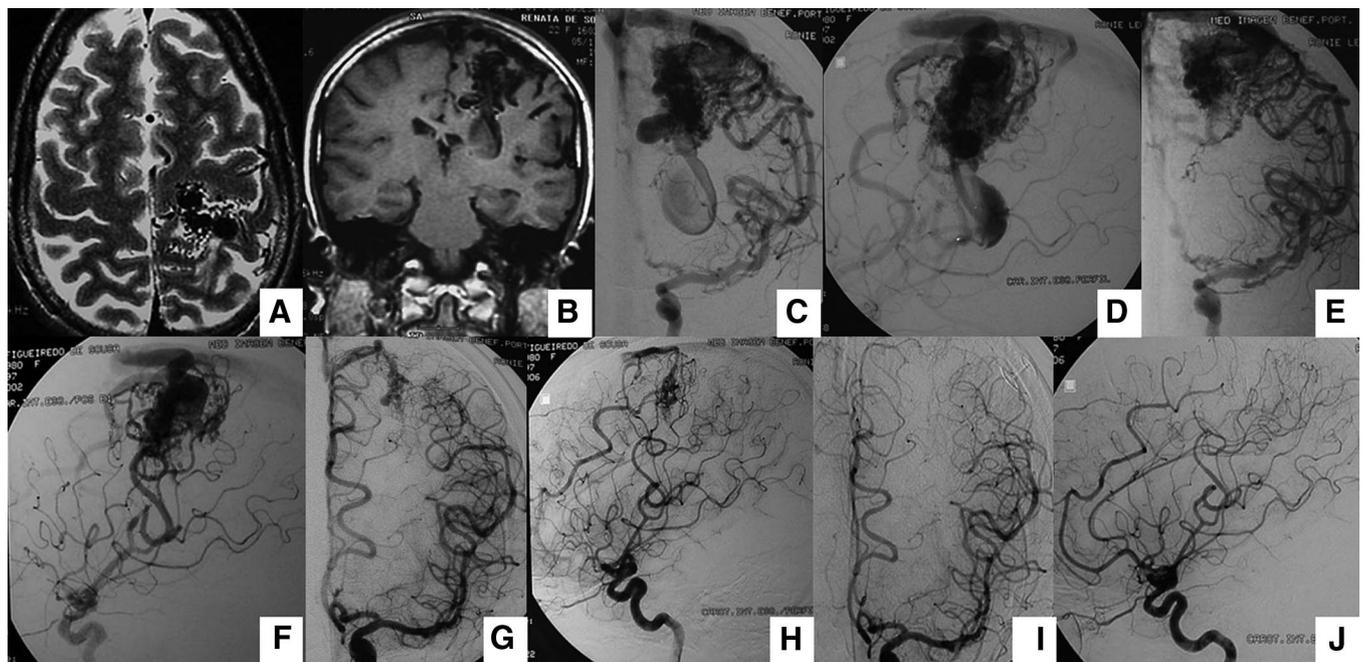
Management of a grade IIIA arteriovenous malformation (AVM) located in the left pre- and postcentral gyri. Axial (A) and coronal (B) magnetic resonance imaging showing the AVM in the left pre- and postcentral gyri. Also note the presence of a large venous aneurysm. Anteroposterior (C) and lateral (D) internal left side carotid angiograms showing an AVM supplied by branches of the middle cerebral artery and the venous aneurysm. The patient was initially treated with embolization (control angiograms shown in E and F), followed by radiosurgery after 3 months. Anteroposterior (G) and lateral (H) angiograms 3 years after radiosurgery treatment. Finally, the patient underwent surgical resection of residual AVM. I and J, postoperative angiogram showing complete AVM resection.
